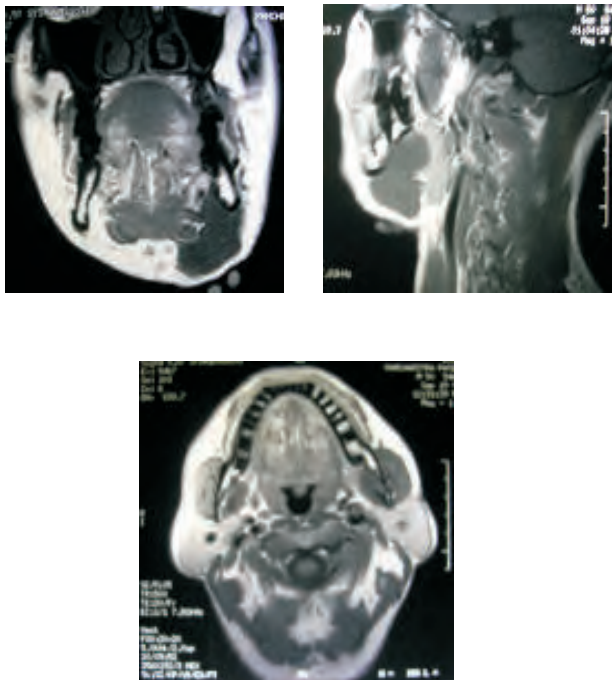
3a), 3b & 3c - MRI Coronal T2-weighted MRI showing a high-signal-intensity lesion in the sublingual and submandibular spaces and extending medially and superiorly along the medial pterygoid muscle.
